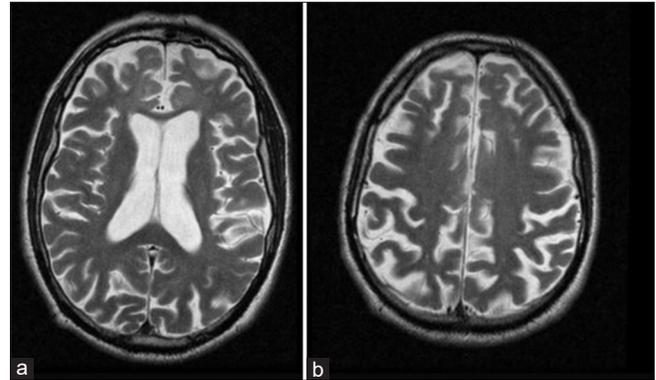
Brain MR T2-weighted axial images showed a typical frontotemporal cortical atrophy and the absence of hygromas.
